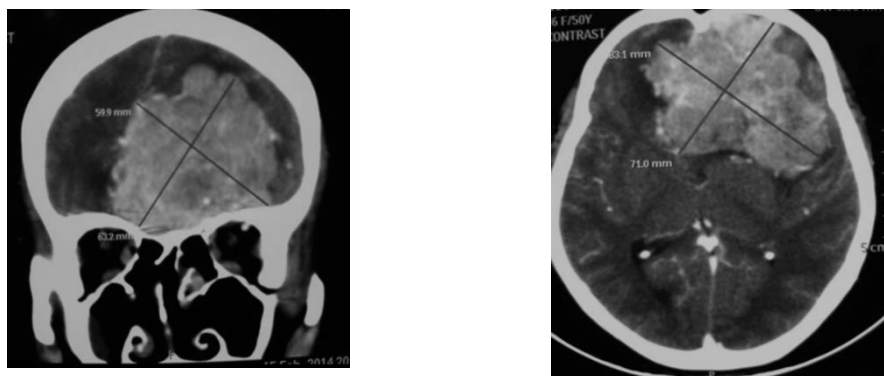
a): Preoperative MRI showing olfactory groove meningiomas
